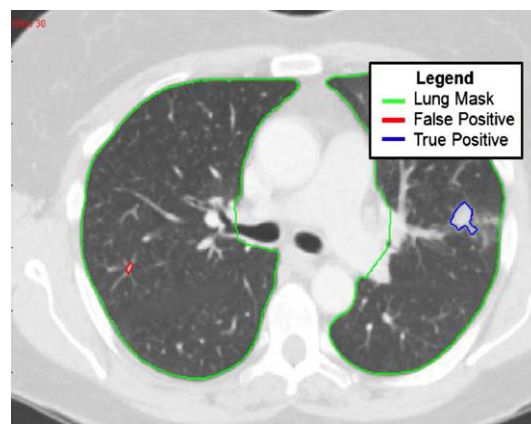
A typical output of the CAD system superimposed on the according CT slice image.
